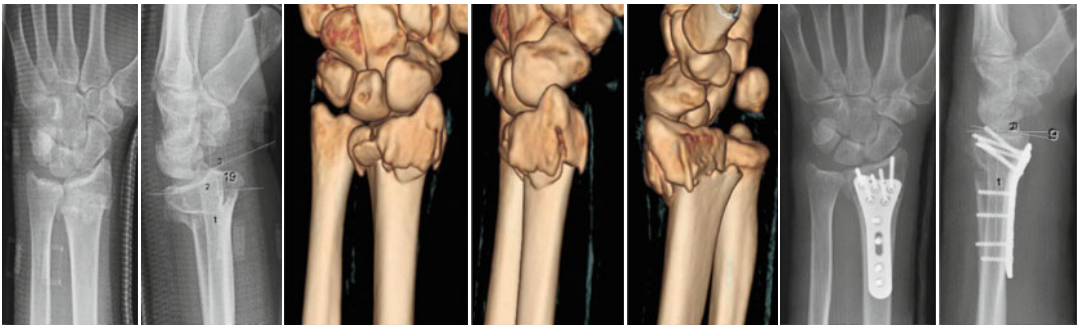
Comminuted distal intra-articular radial fracture with dorsal tilt: conventional radiograph, preoperative 3D CT scan and postoperative control radiograph.
